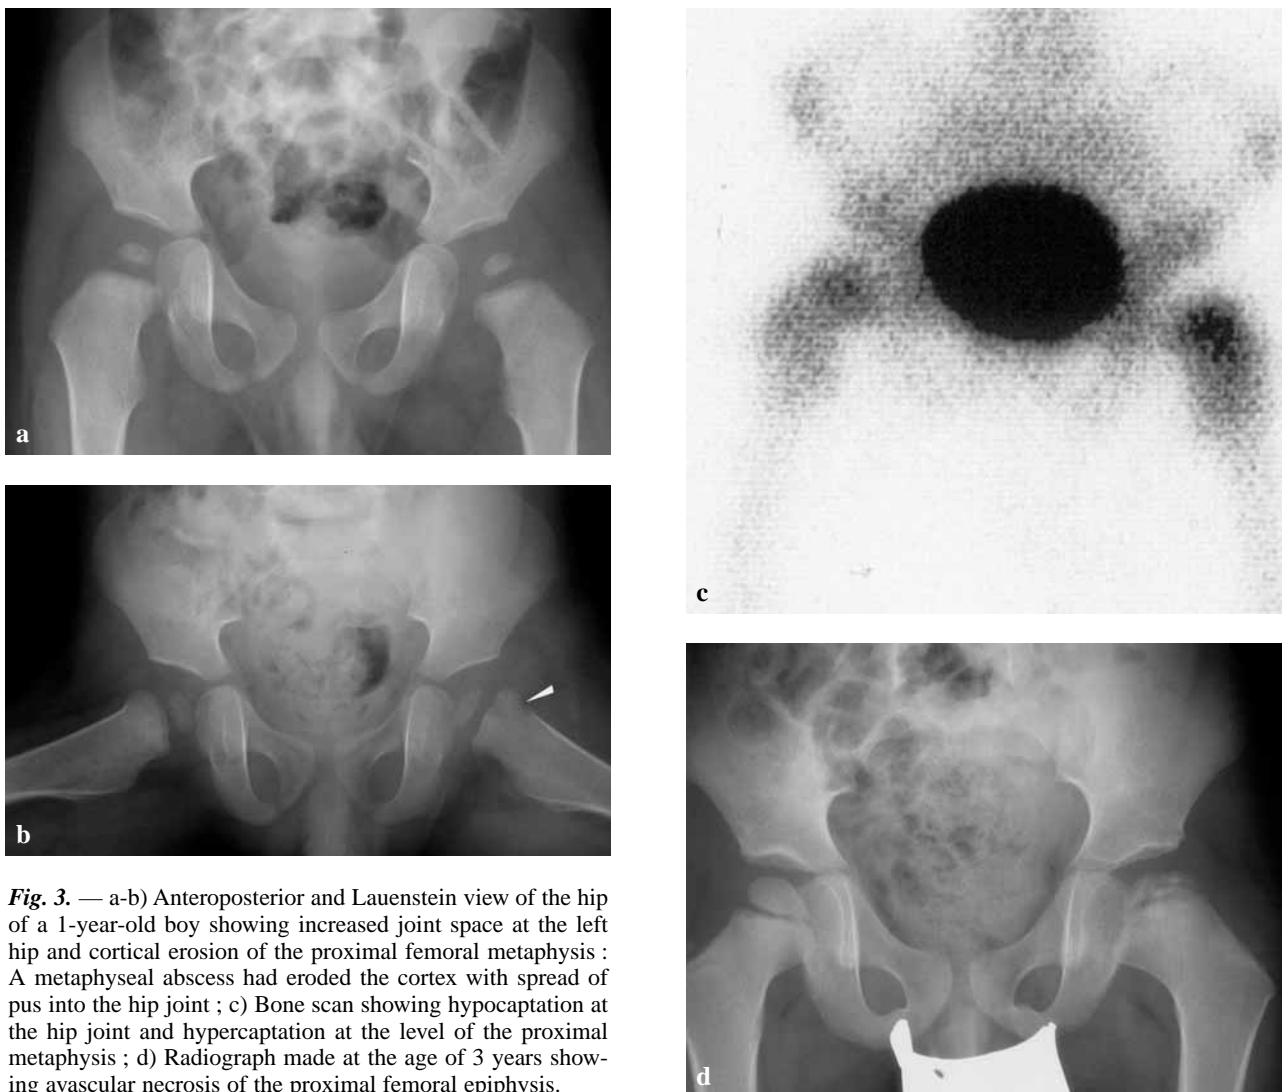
a-b) Anteroposterior and Lauenstein view of the hip of a 1-year-old boy showing increased joint space at the left hip and cortical erosion of the proximal femoral metaphysis : A metaphyseal abscess had eroded the cortex with spread of pus into the hip joint ; c) Bone scan showing hypocaptation at the hip joint and hypercaptation at the level of the proximal metaphysis ; d) Radiograph made at the age of 3 years showing avascular necrosis of the proximal femoral epiphysis.
